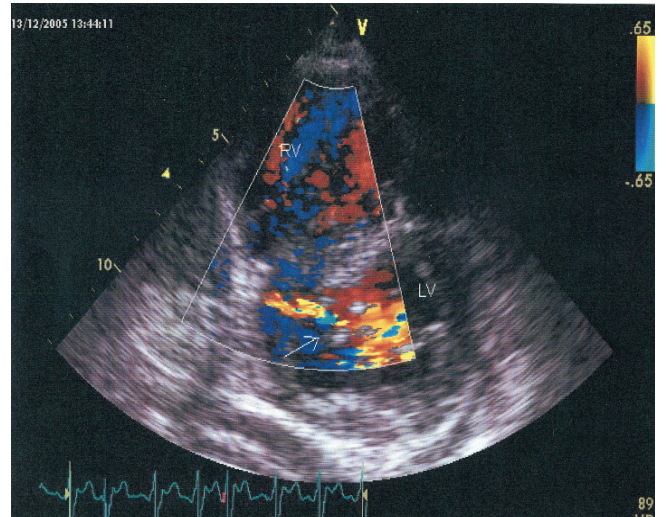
Color flow through ventricular septal rupture (arrow) demonstrated by color Doppler transthoracic echocardiography in parasternal short axis view at mitral valve level. LV; left ventricle, RV; right ventricle.
